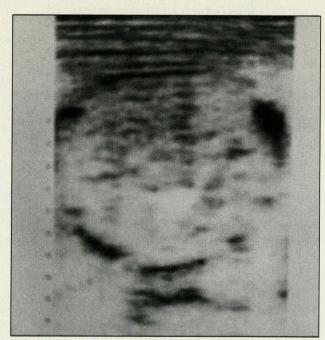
(Case 1). Ultrasonogram at 40 weeks' gestation shows poor bony structure of fetal head.
